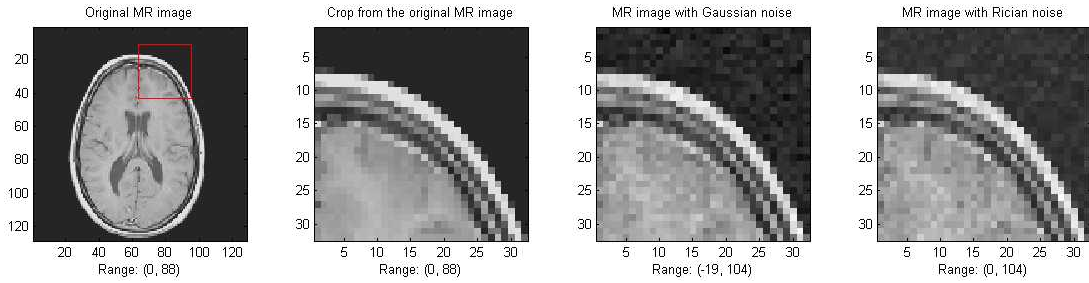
Example of MRI image with added noise (a) Original MRI image (b) Crop from the Original MRI image (c) MRI image with added Gaussian noise (d) MRI image with Rician noise distribution
